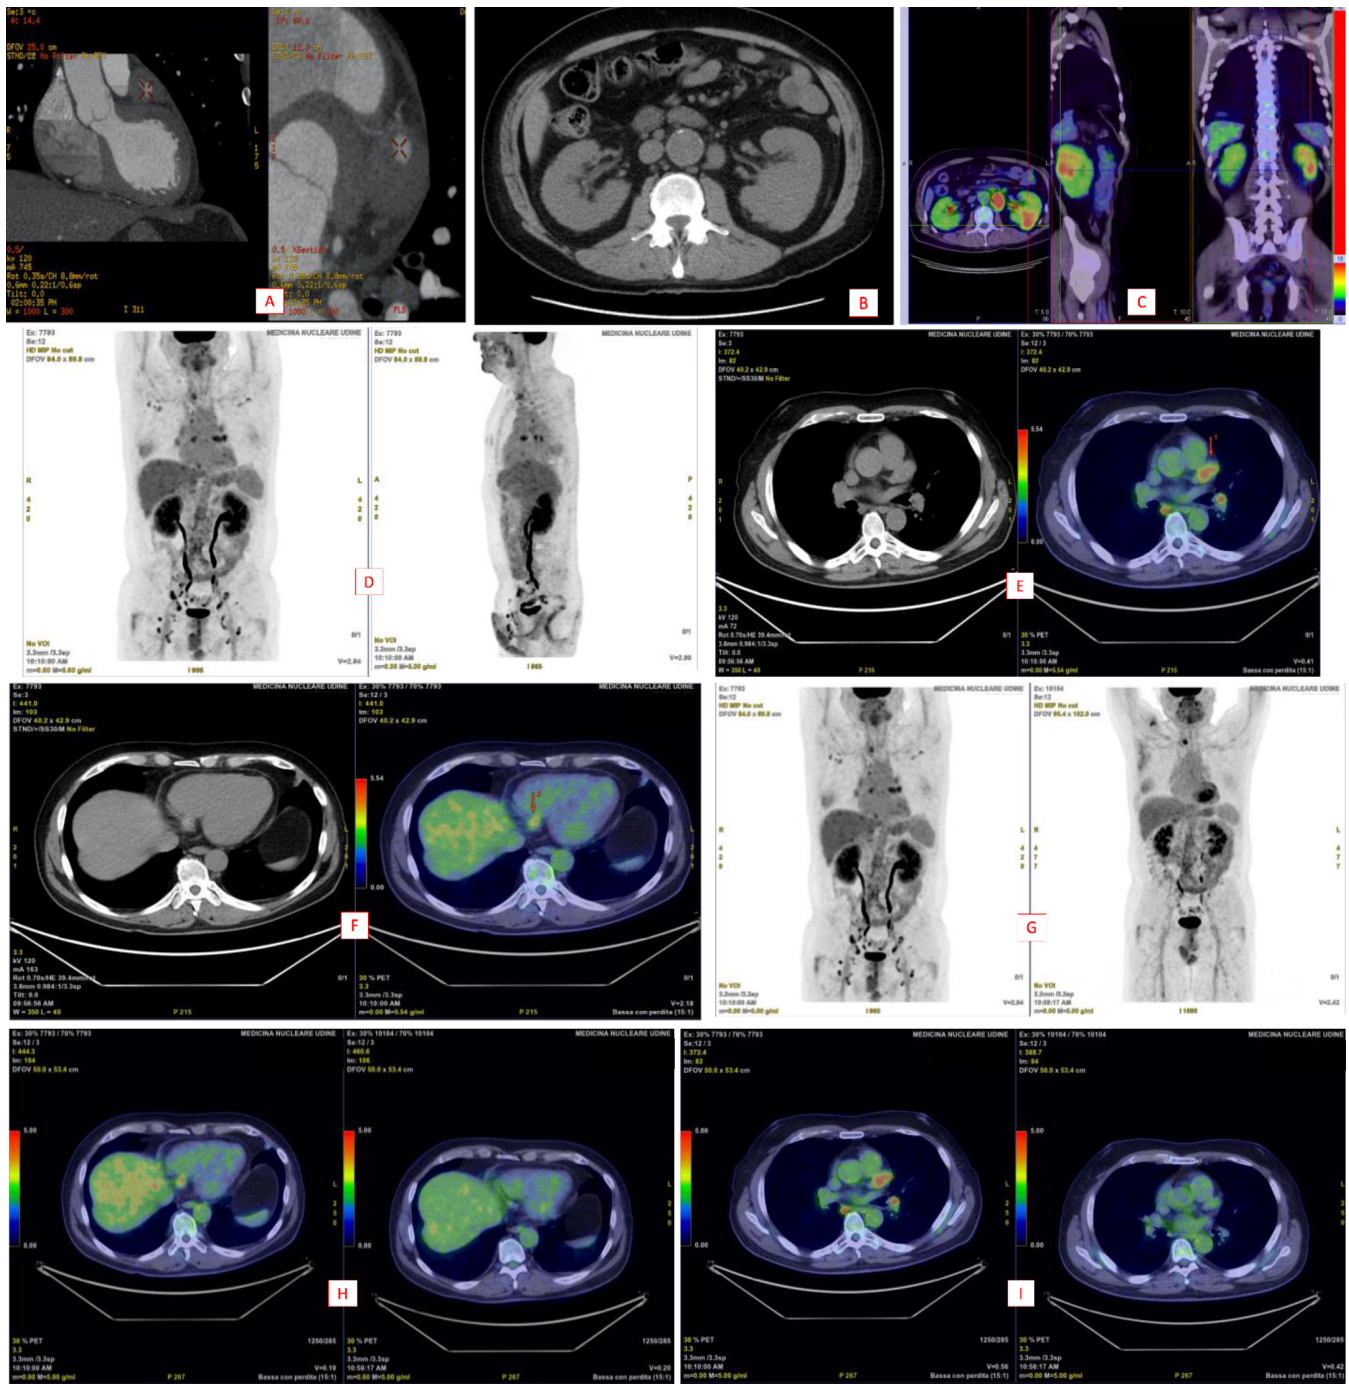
Imaging details of cardiac and lymphoproliferative manifestations. A: Details of aneurismatic dilatation of LDA coronary artery at coronary CT. B-C: Left renal mass and bulky adjacent lymph adenomegalies at abdominal angio CT and PET/CT. D-F: PET/CT caption of diffuse lymph adenomegalies and of coronary aneurisms, suspicious for relapse of lymphoproliferative and cardiac involvement of disease. G-I: Details of PET/CT scan amelioration after therapy, both on lymphoproliferative and cardiac involvement.
